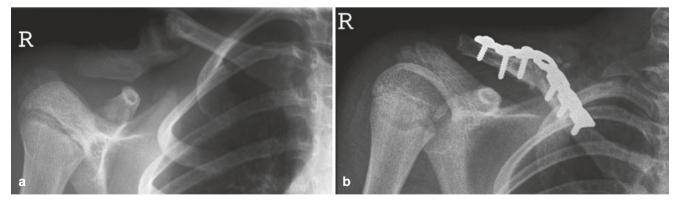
(a) Several months after trauma a palpable lump persisted, radiography showed a post-traumatic pseudoarthrosis. (b) Post-surgical radiograph shows a well-aligned clavicle
